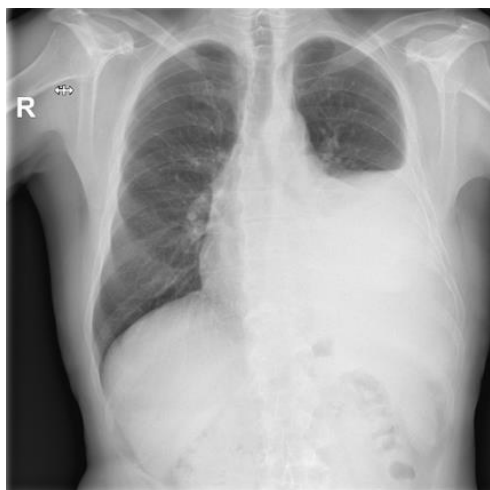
Posteroanterior chest X-ray: pleural effusion in left thoracic cavity
